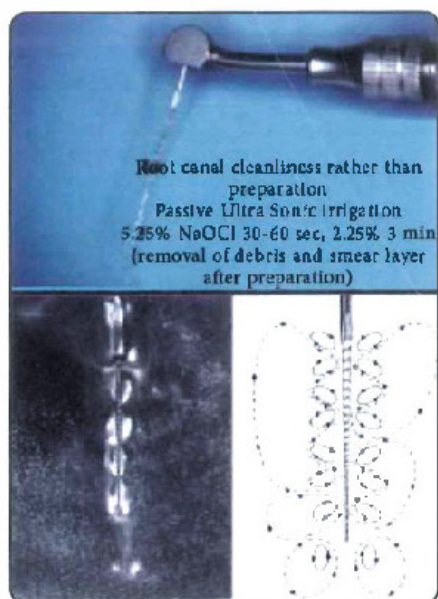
Passive Ultrasonic irrigation causes acoustic streaming which increases the cleaning effect of the irrigant.
